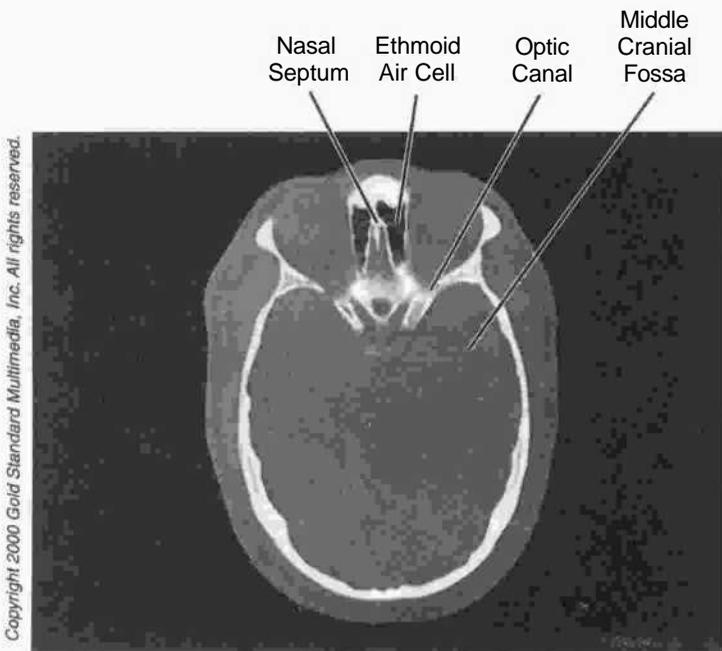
Head and Neck: CT, Skull
